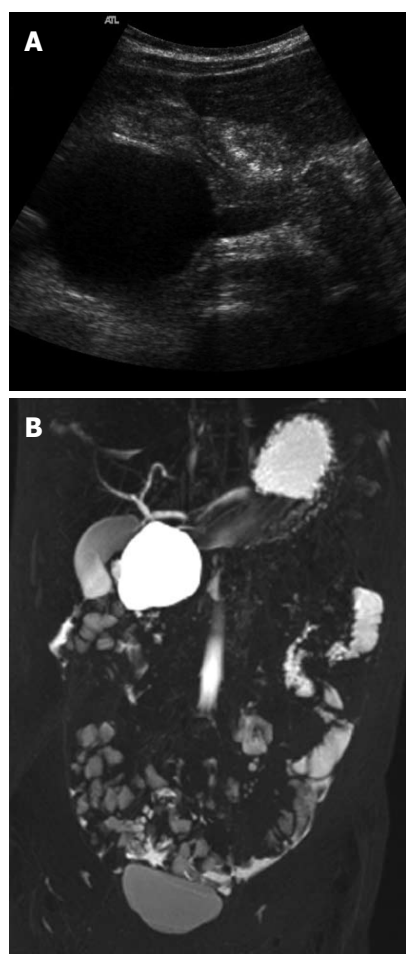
Diagnostic imaging. A: Ultrasound of a cystic duodenal duplication; B: Magnetic resonance scan of a cystic duodenal duplication.
